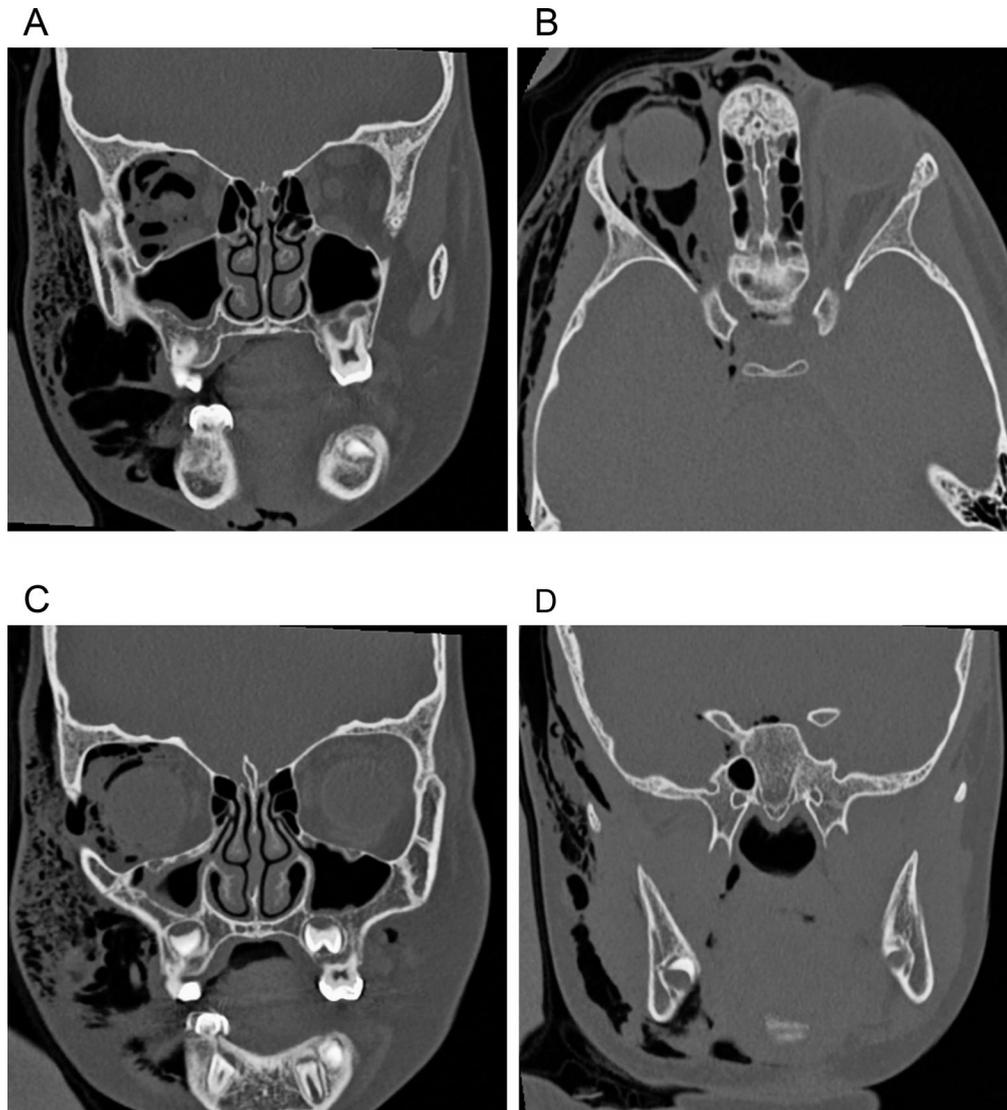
Various sections of the CT scan of the face showing significant subcutaneous, intraorbital, intracranial, and parapharyngeal emphysema. A, B, D; Coronal view. C, Axial view
